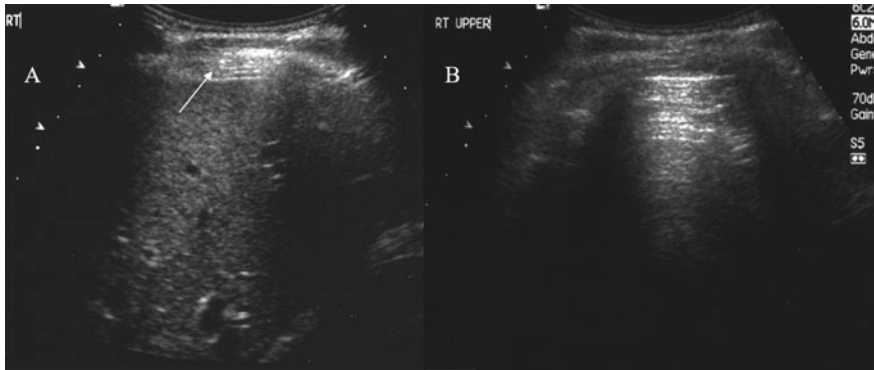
a Transverse view through the liver, with some reverberation artefact over the liver surface, suspicious for free intraperitoneal air. b Repeat ultrasound with the patient now in left lateral decubitus position. The liver is no longer seen due to extensive reverberation artefact from free intraperitoneal air
